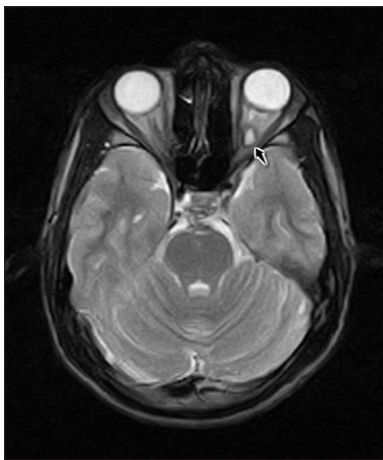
Axial MRI T2W image in 21-year-old patient showing hyperintense cystic lesion in mid portion of left optic nerve (arrow). MRI: Magnetic resonance imaging, T2W: T2-weighted
